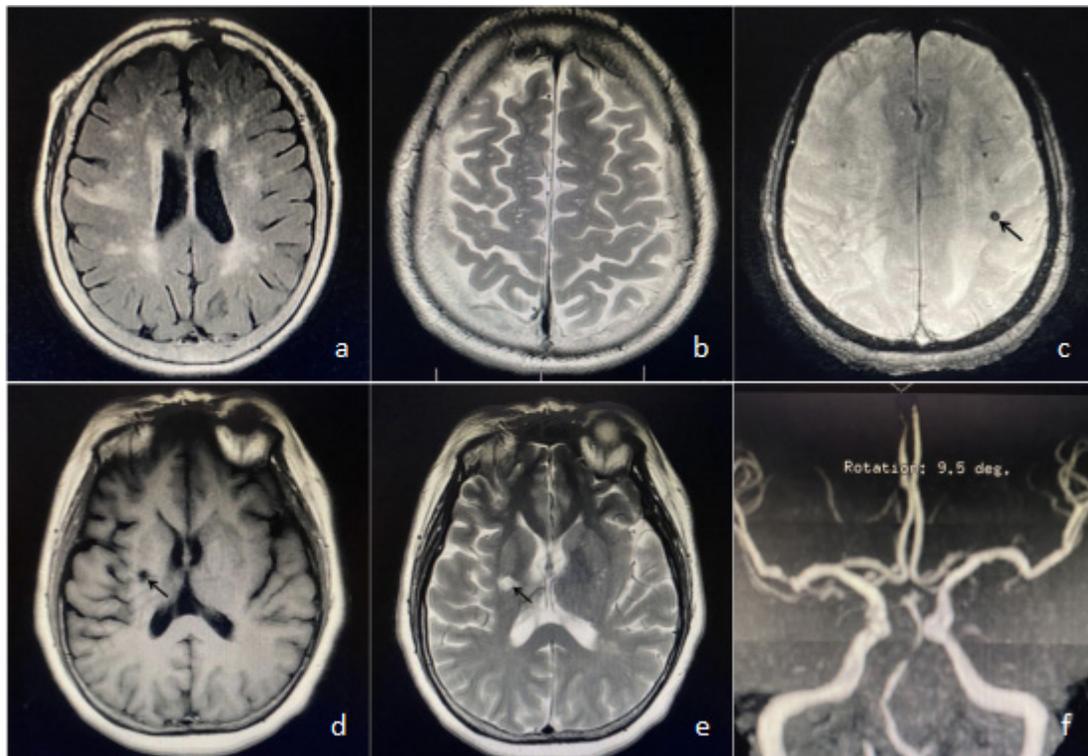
Imaging features: Figure a shows WMH on T2 FLAIR. Figure b shows the EPVS on T2 FSE. Figure c shows CMBs on SWI. Figures d and e shows lacuna. Figure f shows basilar artery stenosis on MRA. (WMH: white matter hyperintensities; EPVS: perivascular space enlargement; CMBs: cerebral microbleeds)
